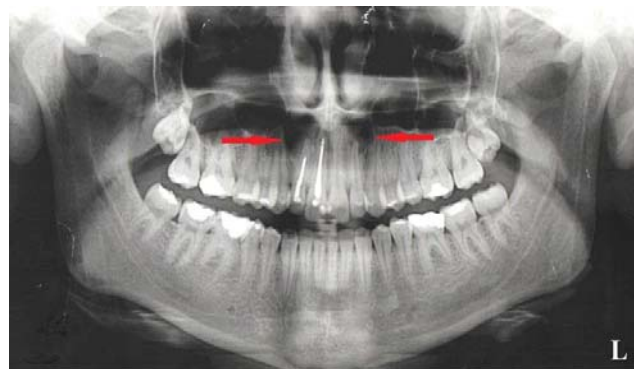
The panoramic radiograph before the treatment.
